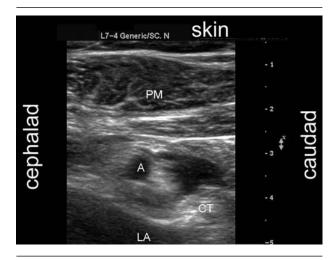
FIGURE 2iii Postero-inferior spread of LA following injection through catheter. CT was inserted posterior to the axillary artery, similar to Figure 2ii. LA = local anesthetic; A = axillary artery; CT = catheter tip; PM = pectoralis muscle.
